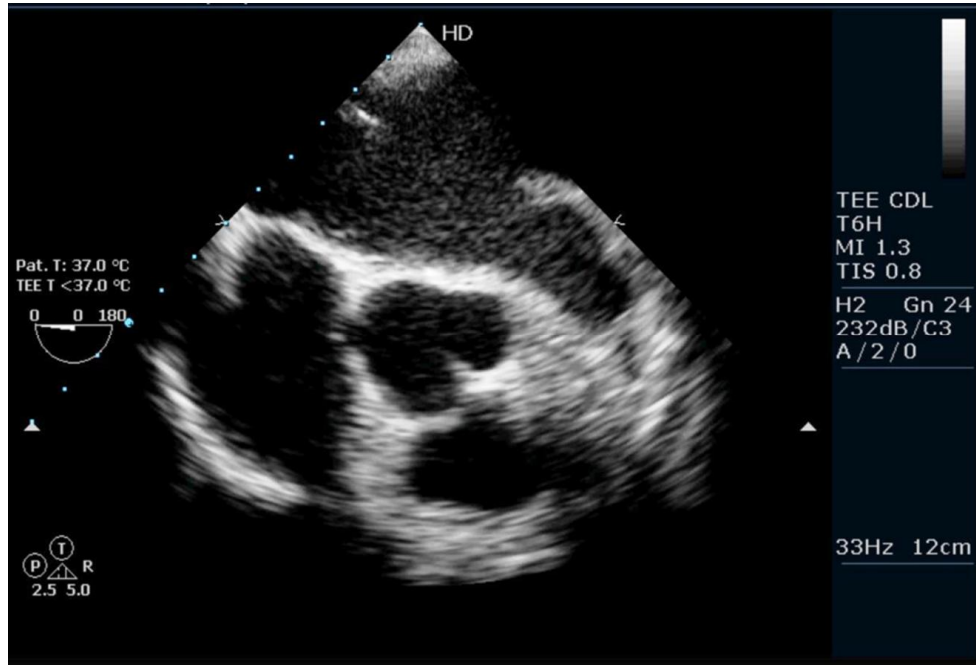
Transesophageal imaging of the patient at zero degree showing grade I spontaneous ECHO contrast in LA with no clot in left atrium/atrial appendage
